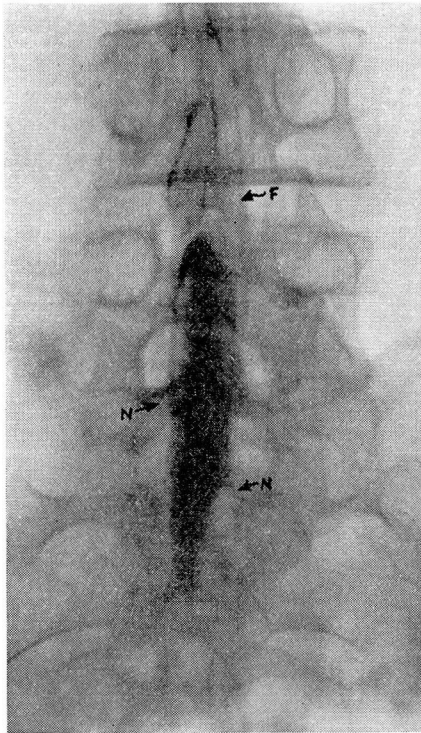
Visualization of the caudal sac with 10 cc. thorotrast. The substance had been allowed to diffuse widely before the roentgenogram was made. Fibers of the cauda equina (F) and the extension of the subarachnoid distension along the nerves are seen (N).
